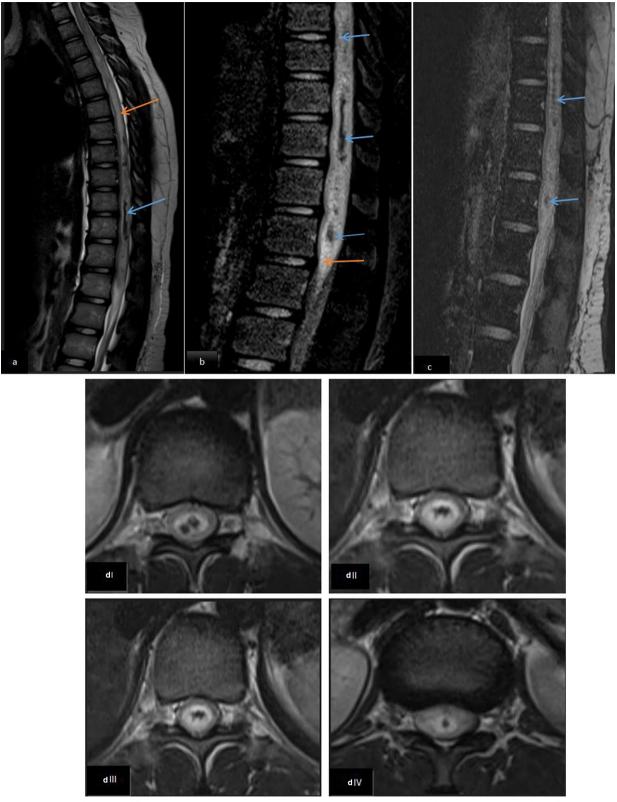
a T2 W sagittal image and b FLAIR sagittal image showing a long-segment T2 hyperintense signal (orange arrow) extending till conus medullaris, with few hypointense areas (blue arrows) in between. c Gradient sagittal image showing few areas of blooming within the spinal cord(blue arrows). d I–IV T2 W axial images at T8, T10, T11 and T12 levels, respectively, showing expansile T2 hyperintense spinal cord lesion with few hypointense areas within. e T1 fat-saturated pre-contrast sagittal image. f T1 fat-saturated post-contrast sagittal image showing heterogeneous areas of post-contrast enhancement (white arrows)
